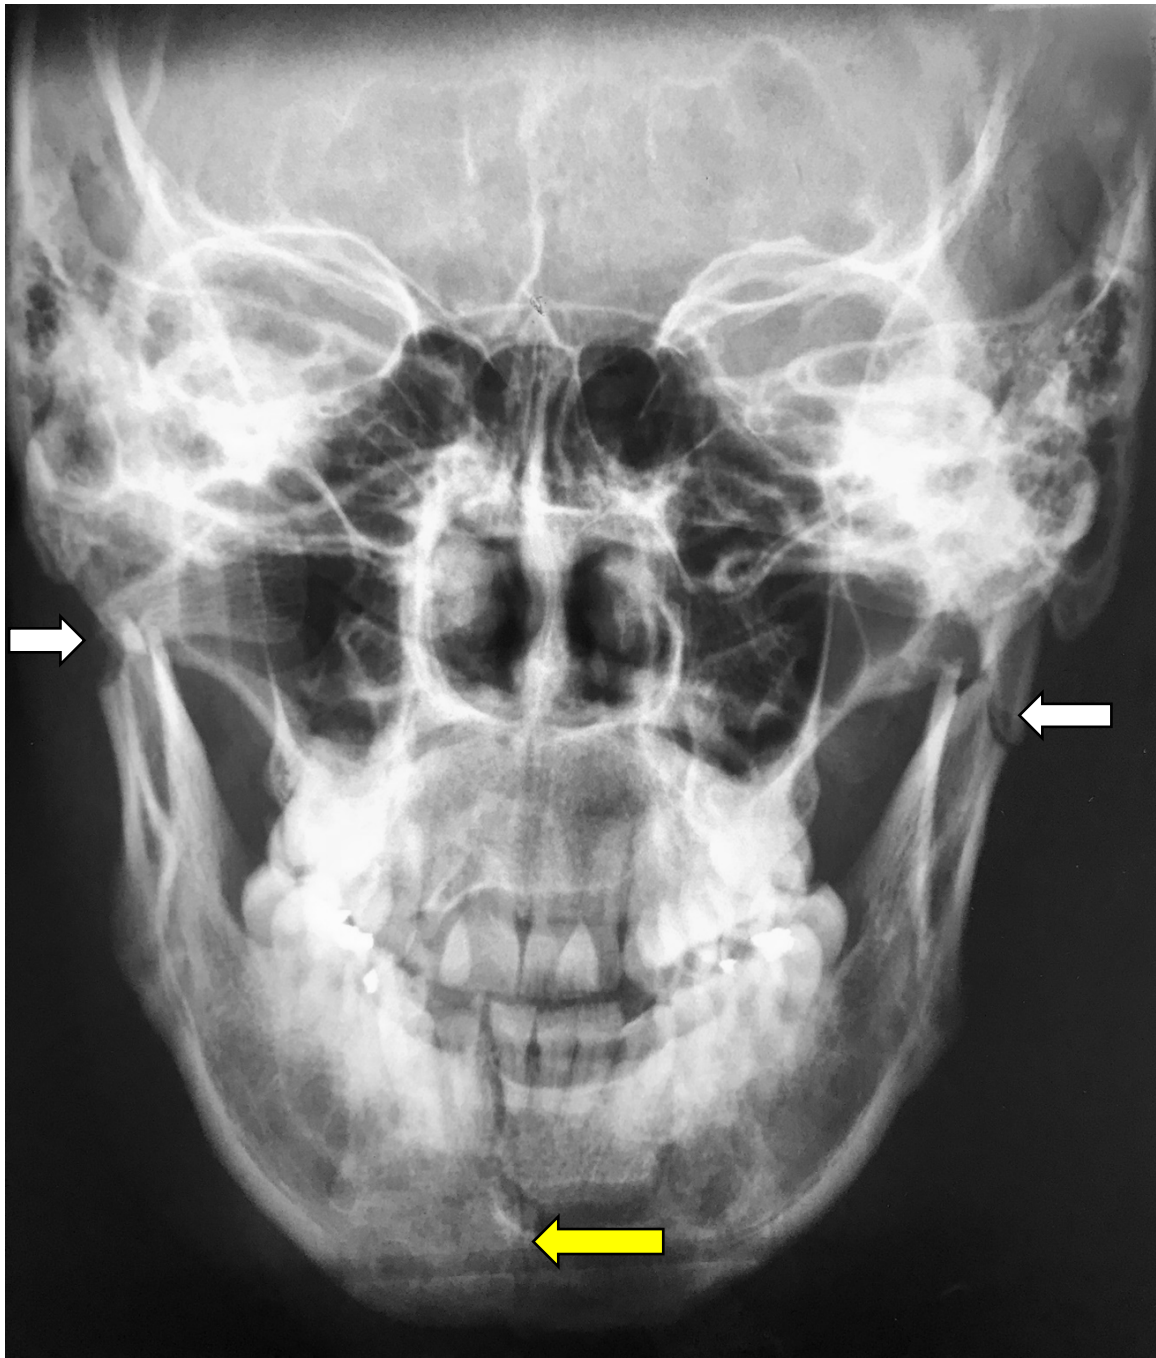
Postero-Anterior (PA) mandible preoperative X-ray showing bilateral condylar fractures (white arrows: WITS Type III right and Type II B left sides) with a symphyseal fracture (yellow arrow).
